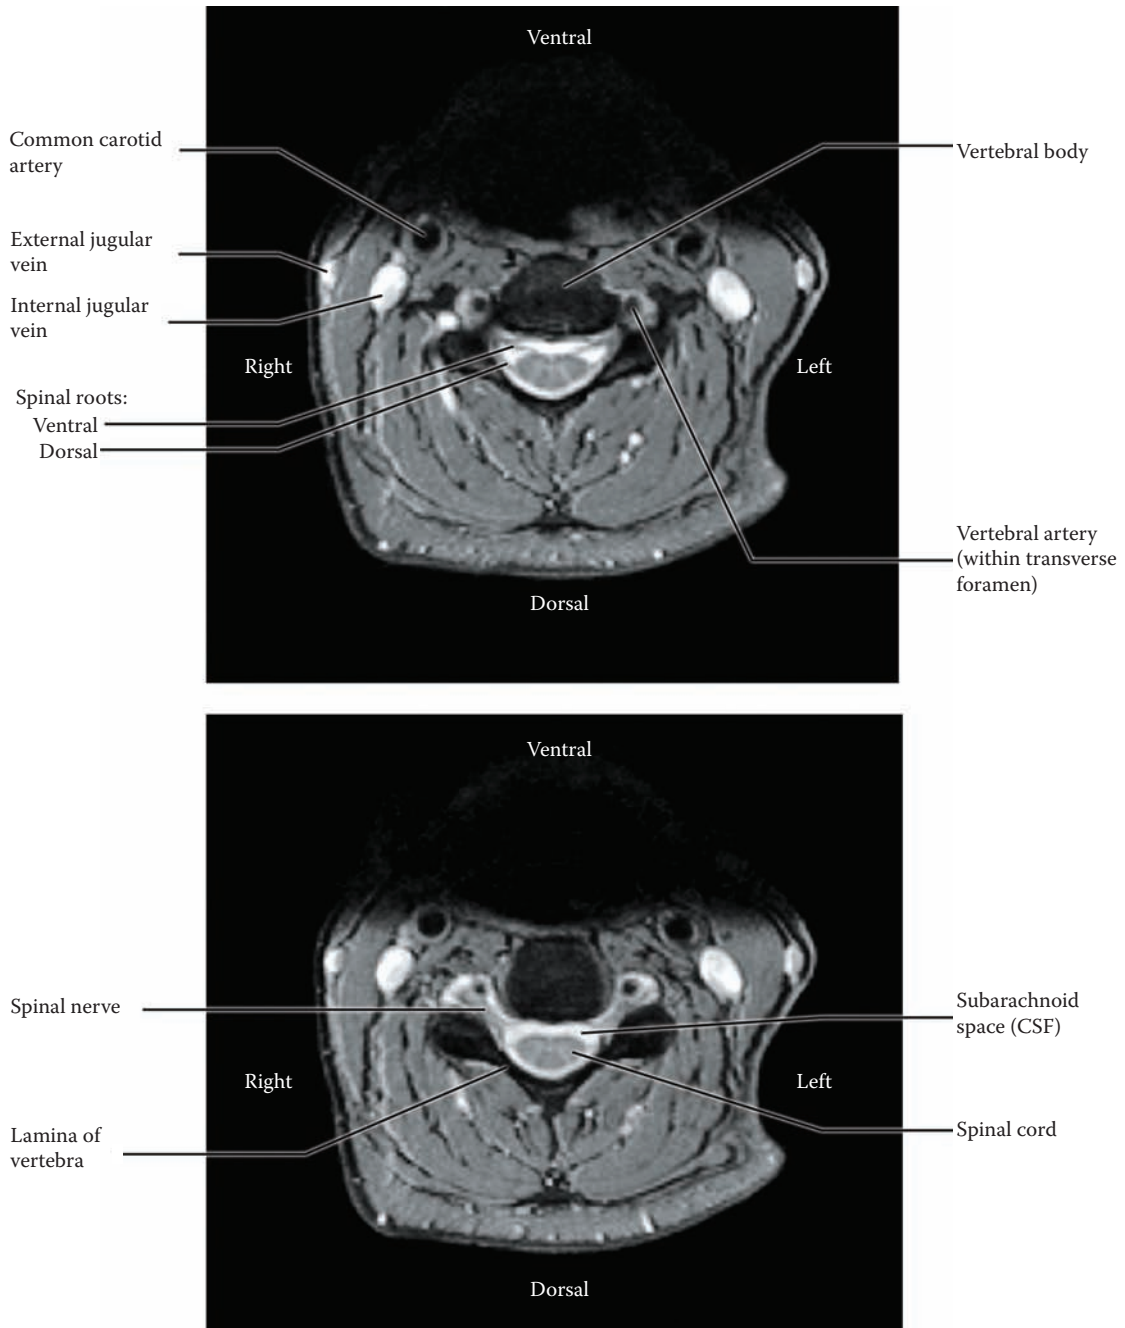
Spinal Cord 7 — MRI: Axial View (radiograph)
